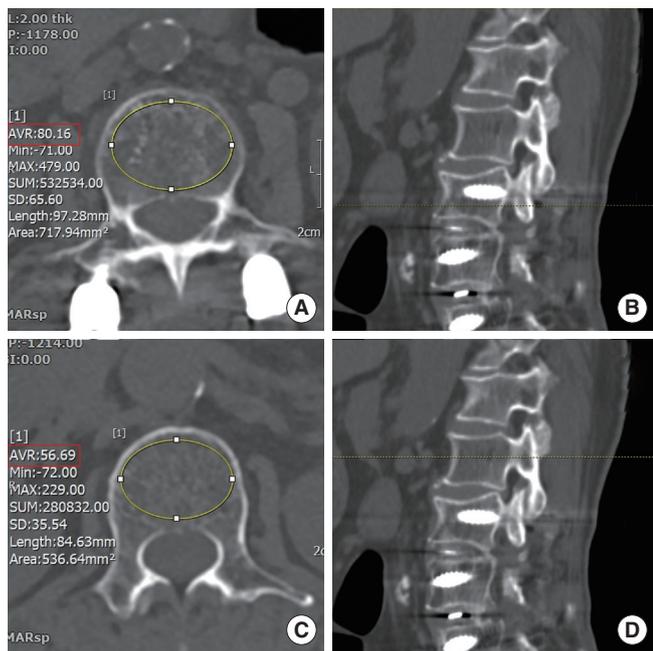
Example of Hounsfield unit (HU) assessment at instrumented and noninstrumented levels. This patient underwent L3–S1 fusion surgery. (A) Example of HU measurement at an instrumented vertebra. The region of interest (ROI) was drawn to encapsulate the maximum cancellous bone volume while avoiding cortical bone. The average HU measured was 80.16. (B) Sagittal computed tomography (CT) image corresponding to the axial slice shown in panel A. HU measurements at instrumented levels were obtained on the first axial cut caudal to the instrumentation-induced halo. (C) Example of HU measurement at a noninstrumented vertebra, using the same ROI method as in panel A. The average HU measured was 56.69. (D) Sagittal CT image corresponding to the axial slice shown in panel C. HU was measured on axial cuts taken at the midpedicle level for noninstrumented vertebrae.
